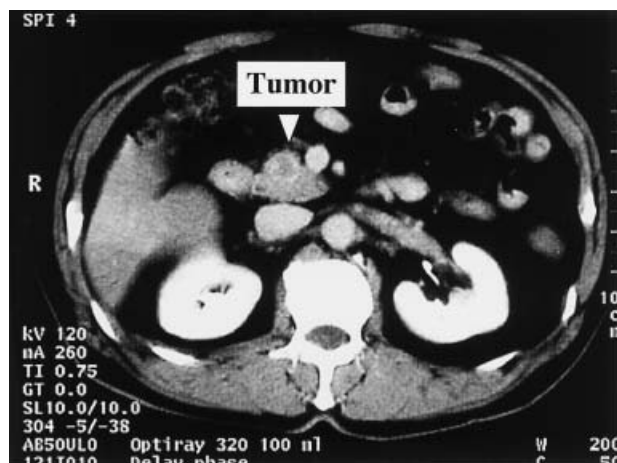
CE-CT revealed a low-density mass 2cm in diameter in the pancreatic head.
